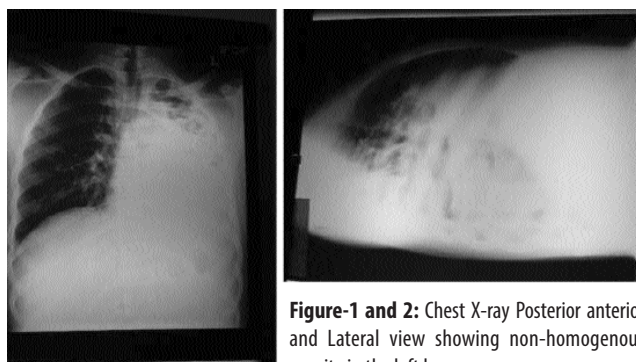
Chest X-ray Posterior anterior and Lateral view showing non-homogenous opacity in the left lung.
